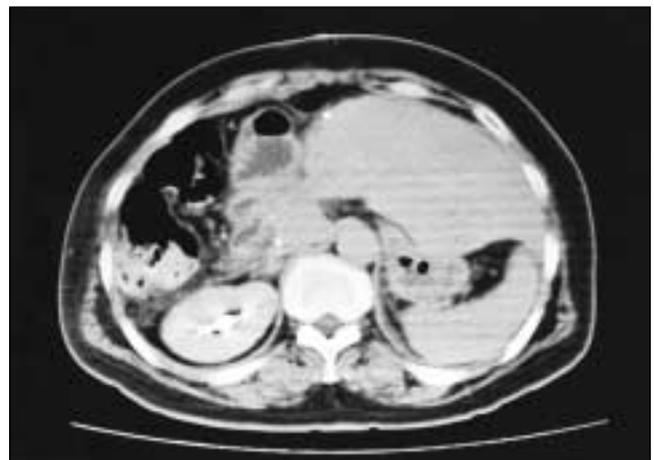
Left: computed tomography scan in a patient with alveolar echinococcosis showing invasion of the middle hepatic vein. Right: CT scan of the same patient 1 month after right extended hepatectomy.
